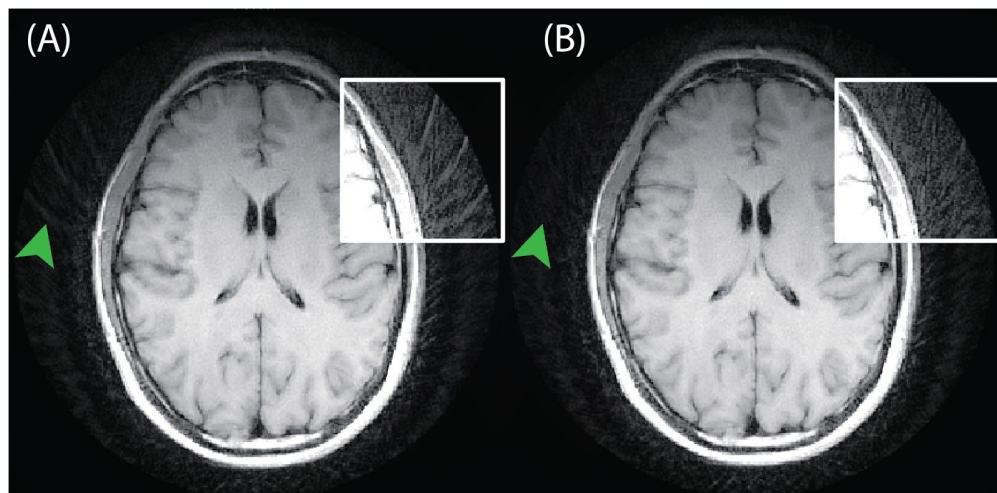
The same PMC corrected T1-FLAIR PROPELLER data was reconstructed using both the standard orthogonal blade GRAPPA (A) method and the proposed PMC adapted version (B). The reduction of PI artifacts can be seen on both sides of the head in the up-scaled square and as pointed out by the green arrows.
